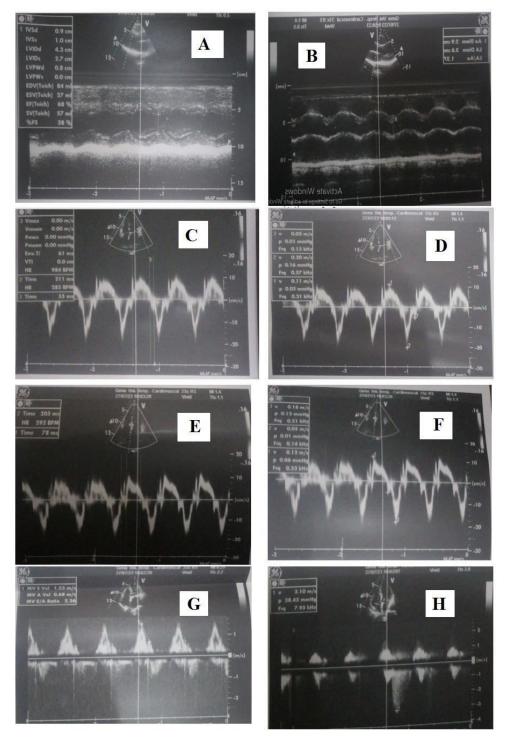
TDI Dimensions: A: By M-Mode, Normal LV dimensions & systolic function.B: By M-Mode, Normal LA & Aortic Root dimensions. C: By TDI Lateral aspect show IVRT =55ms, ET= 211ms, IVCT= 61ms D: By TDI Lateral aspect show S`=0.11m/s, E`=0.20m/s, A`=0.05m/s. E: By TDI Septal aspect show IVRT =78ms, ET= 205ms, IVCT= --ms. F: By TDI Septal aspect show S`=0.12m/s, E`=0.05m/s, A`=0.18m/s. G: By Pulsed doppler, MV E vel.=1.55m/s, MV E/A ratio  $\geq$  2. H: By Cont. doppler, TR jet vel.=3.10m/s, TR jet pressure=38 mmHg, PASP=48 mmHg
